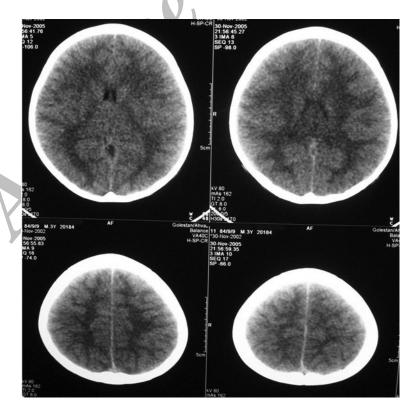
CT scan showed a diffuse brain edema
